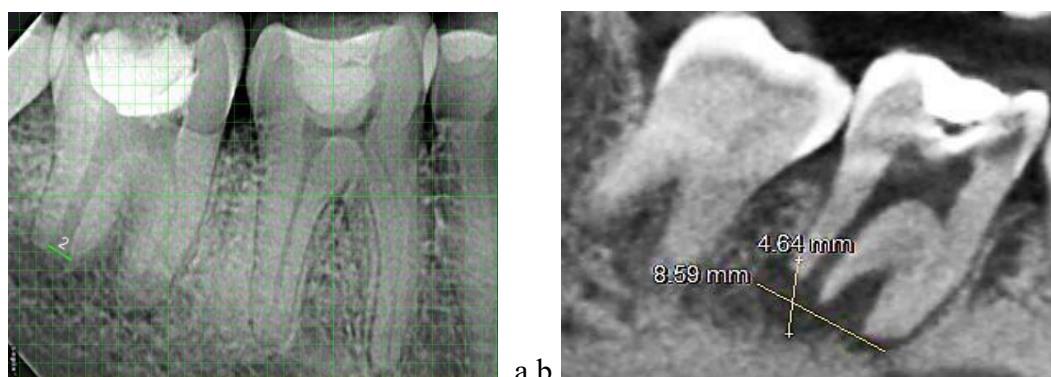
Radiovisiogram of tooth 47 (a). CBCT section of tooth 47 (b).
